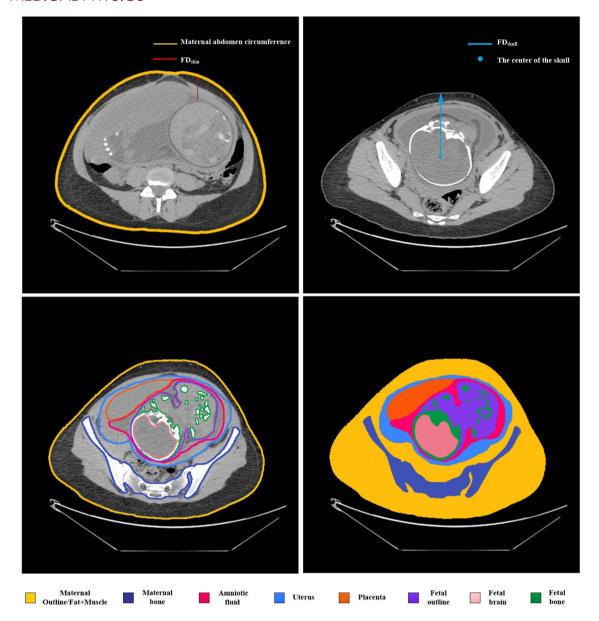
CT images of a pregnant female patient at 35 weeks of gestation showing the segmented organs and measurements of maternal abdominal circumference, fetal skin depth (FD_{skin}), and fetal skull depth (FD_{skin}) distances.
